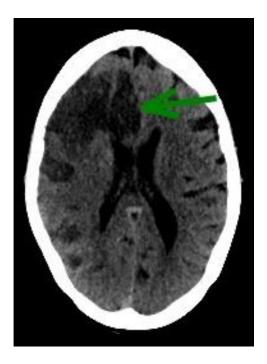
CT noncontrast axial showing right ACA and MCA infarct.
